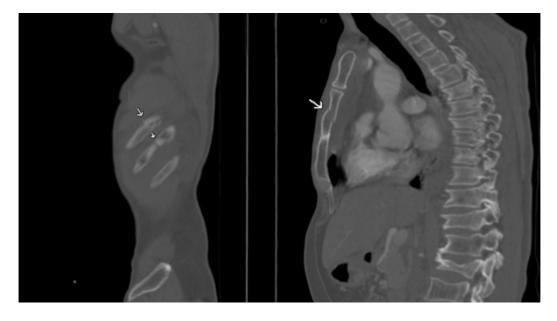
Significant extravascular findings that provide an alternative explanation of clinical symptoms. The patient presented to the emergency room with history of motor cycle accident with acute chest pain. Computed tomographic angiography of the whole aorta shows no significant vascular finding. However, there were two significant extravascular findings that can explain clinical symptoms, i.e. fracture sternum and fracture lateral right 8th and 9th ribs and right hemopneumothorax.
